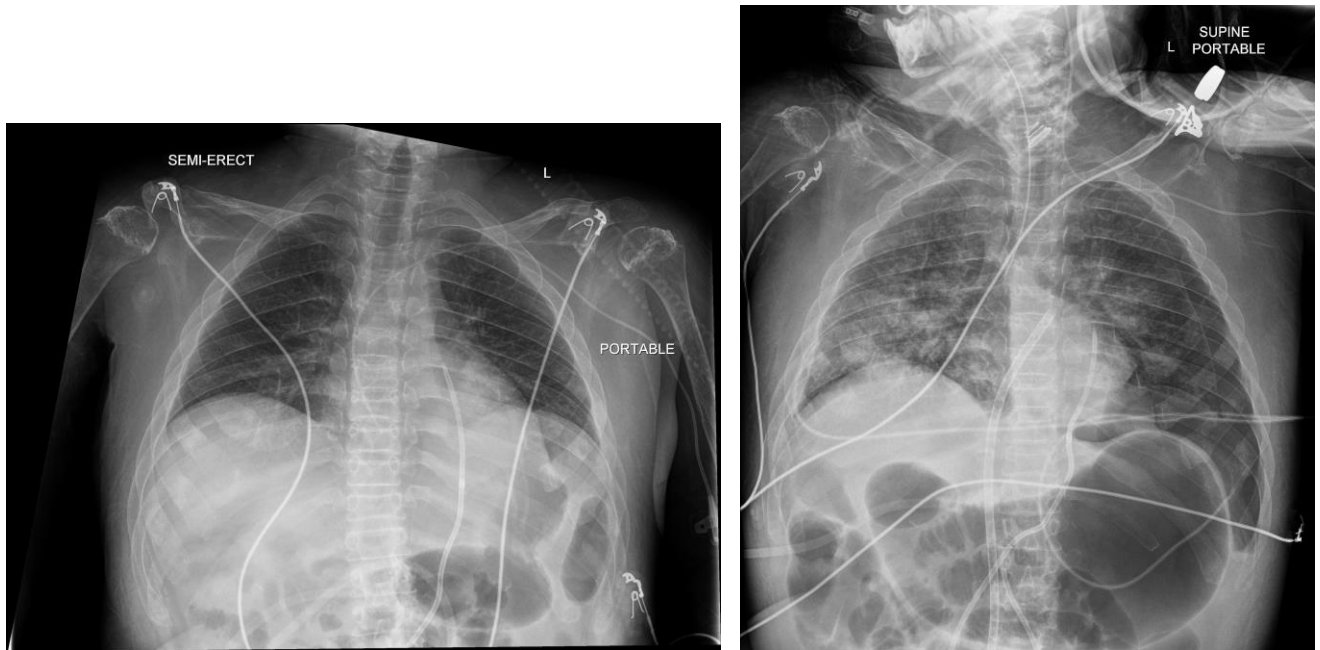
Chest X-ray at two timepoints on day 6 post-dosing. Rapid evolution of Chest X-ray findings of ARDS developing in an 8.5 hr interval on day 6 (left: T0, right: T8.5 hrs).
